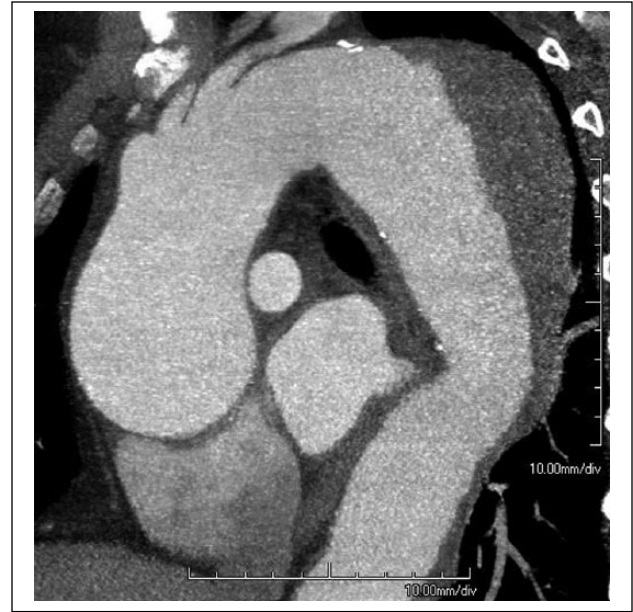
Computed tomography (CT) angiography in Marfan syndrome. Sagittal maximum intensity projection of a CT angiogram performed in a patient with a diffusely aneurysmal thoracic aorta. There are extensive mural thrombi in the descending segment (asterisk).
